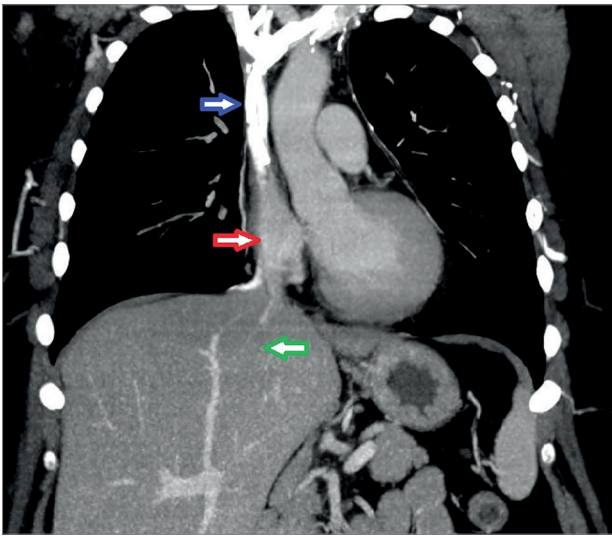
Portal phase of abdominal computed tomography showing subtotal thrombus within the inferior vena cava (red arrow) and a heterogeneous hepatic parenchyma with hypodensity especially at the left lobe (green arrow).
